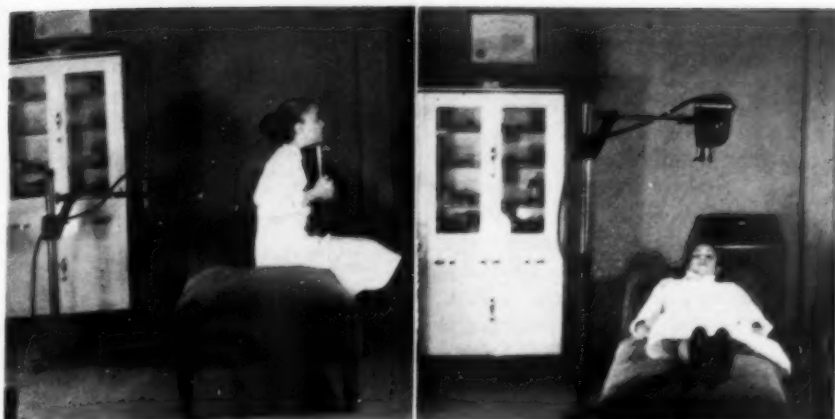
Use of the x-ray stand for roentgenography in upright and prone positions.
